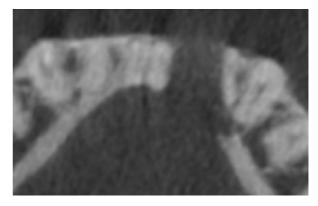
Axial cone beam computed tomography (CBCT) scan showing radiolucency thinning and effacing the facial and lingual cortex of the mandible, with tumor expansion on the facial aspect.
